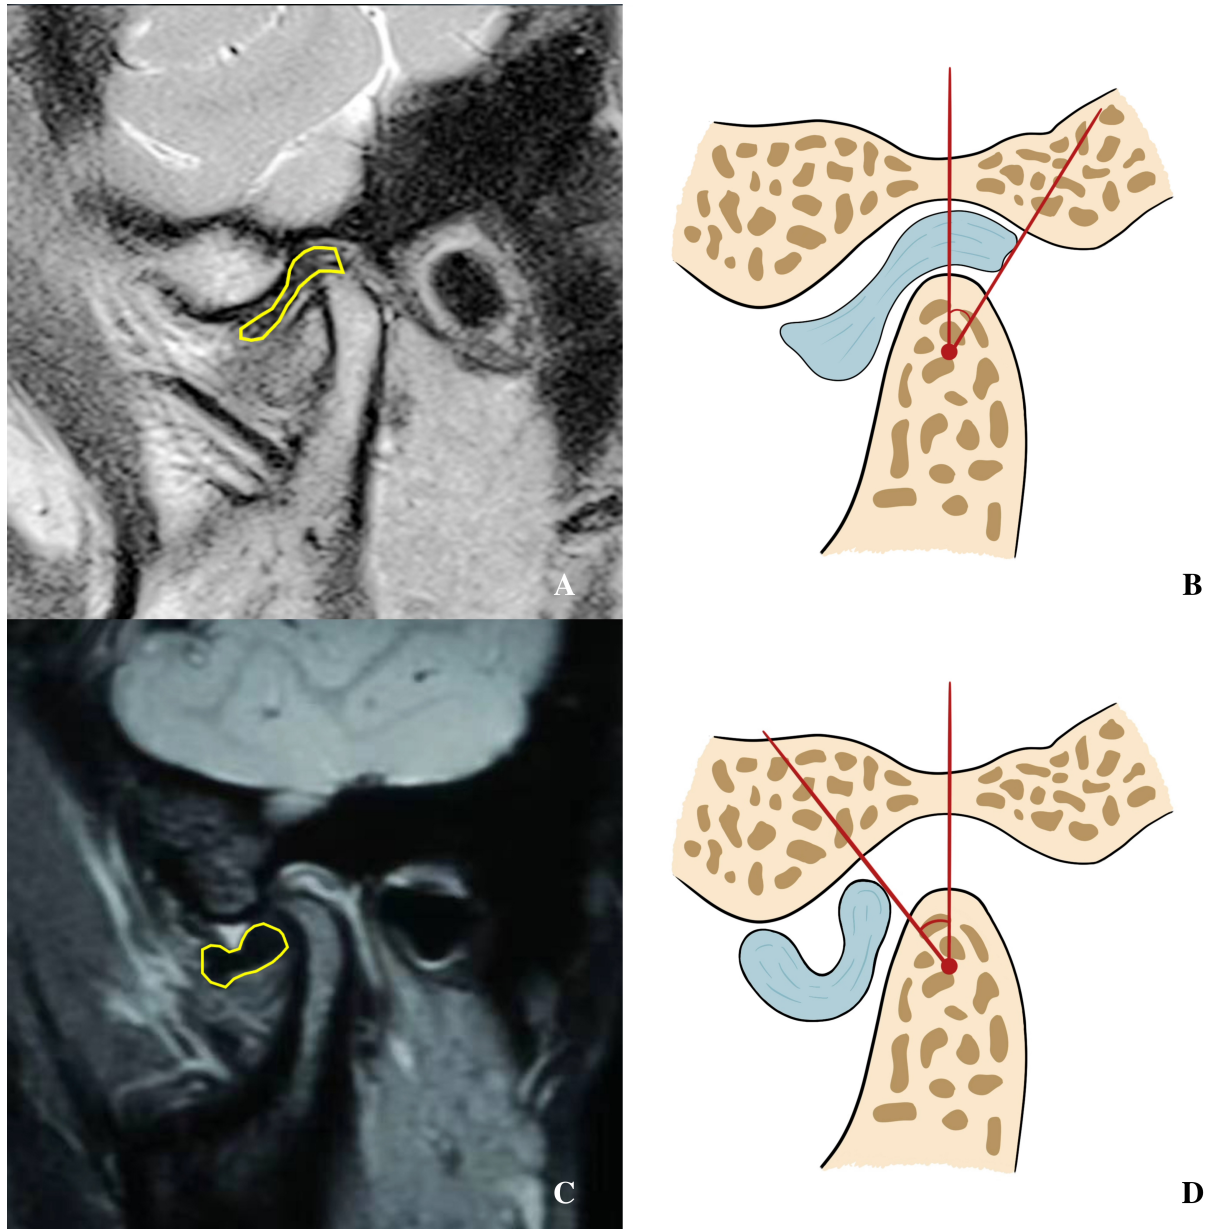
The angle diagnostic method of DD. The Chinese Stomatological Association provided guidelines in 2020 which are as follows: when the mouth is closed, the top of the condyle and the center of the condyle is used as line 1; the posterior edge of the posterior band and the center of the condyle is used as the line 2. When the angle between these two lines is larger than 15° , DD can be defined. (A,B) MRI of healthy joints. (C,D) MRI of DD joints.
